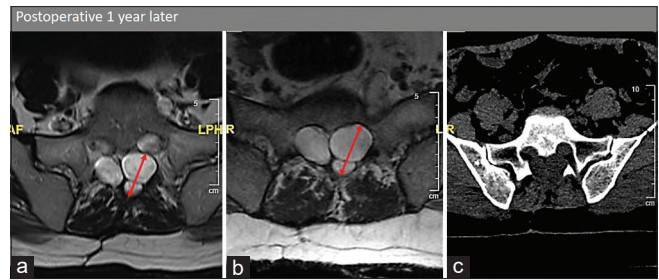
The images where the progression was detected. (a) The diameter of the widest section of the tumor was 21 mm on the magnetic resonance images that were obtained approximately 1 year ago. (b) The widest diameter of the mass was measured to be 24 mm on the magnetic resonance image that was obtained at the time of the study. (c) The destruction that the tumor created in the sacrum was visible in the new computed tomography image
